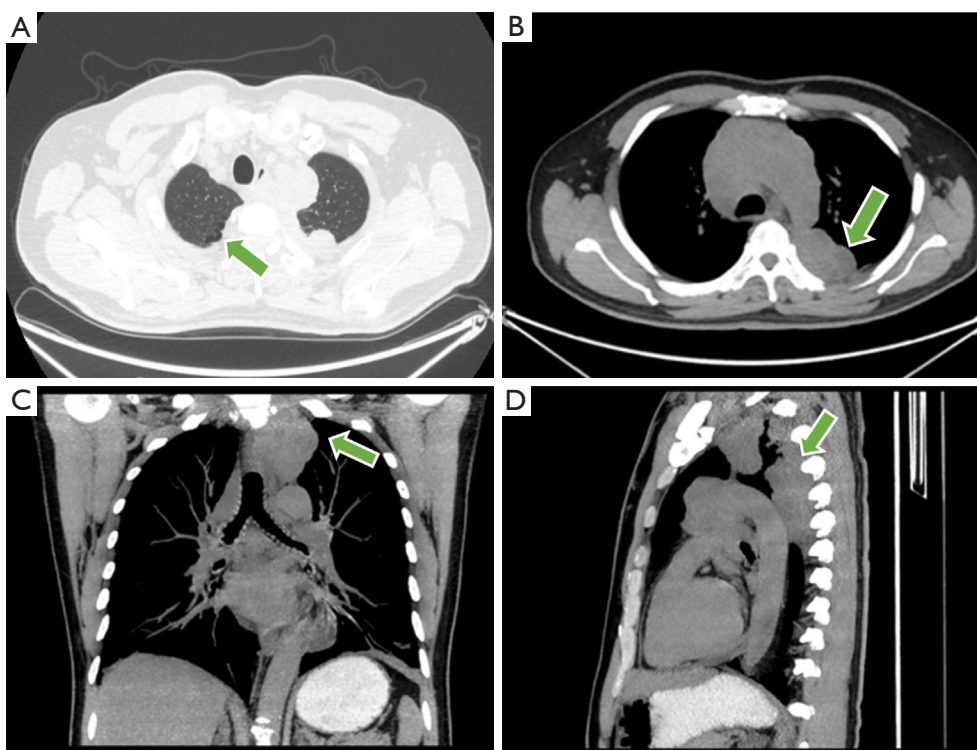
Computed tomography and MIP images of the patient. (A) Presence of a limited distribution of rounded, wall-less hypodense areas in the subpleural of the apical segment of the right upper lobe of the patient's lungs (green arrow). (B) Axial bit MIP image displayed a large mass in the mediastinum left pleura region, invading the rib on the left, soft tissues around the left posterior upper back (green arrow). (C) The coronal MIP image showed the mass as an irregular nodule, encircling the large mediastinal pericardial vessels (green arrow). (D) The sagittal MIP image showed the mass involved in the aorta and multiple thoracic vertebrae (green arrow). MIP, maximum intensity projection.
